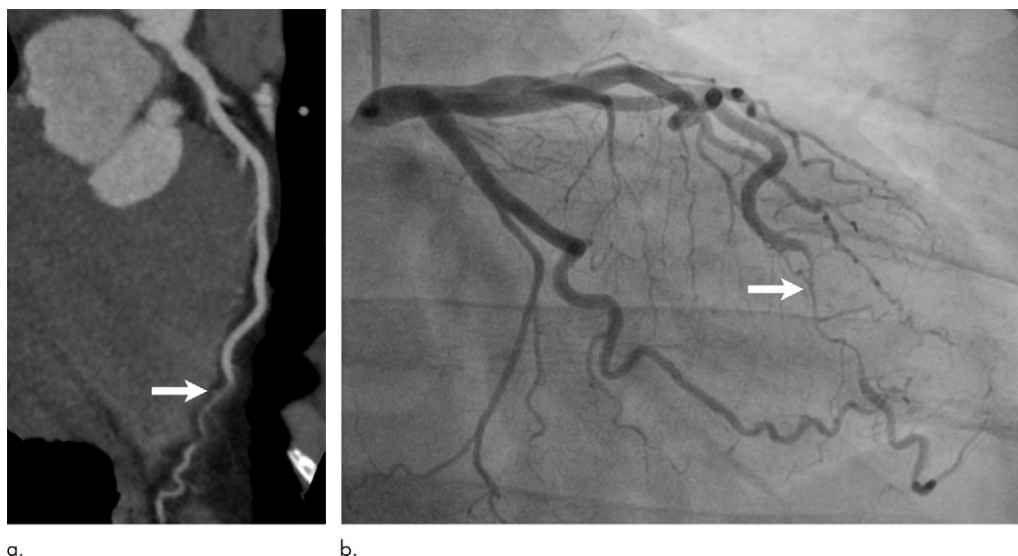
(a) Curved planar reformatted coronary CT and (b) coronary angiograms in a 35-year-old woman who presented with chest pain show tapered, smooth, and diffuse narrowing of distal left anterior descending coronary artery (arrow).
